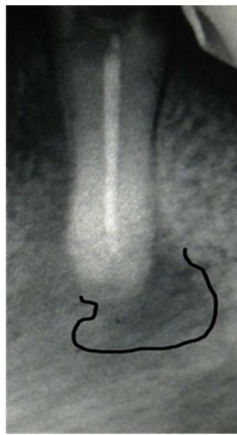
Spot dental X-ray of tooth 45 of the 65 year-old female patient K. The state of the tooth before treatment (a). The state of the tooth following 2 days after treatment (b).
